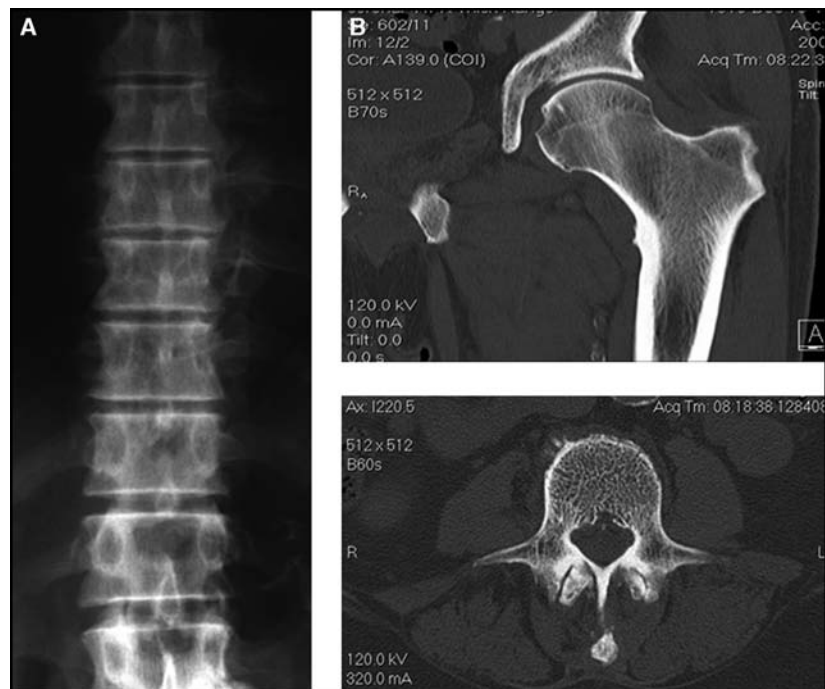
A, X-ray of the spine, showing straight, symmetric and well-delineated vertebral bodies, notable is the lack of degenerative joint disease or compression. B, CT of the spine and hip. Note prominence of trabeculae.
